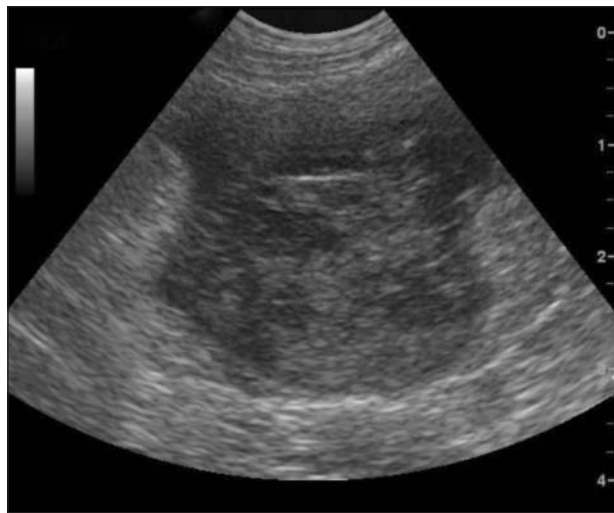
Transverse ultrasonographic image of the abdomen of a 3.7-year-old rabbit that was evaluated because of anorexia and lack of fecal production during the preceding day; on physical examination, palpation of the cranial portion of the abdomen elicited signs of pain and gas was palpable in the stomach. In this view, the caudate liver lobe is enlarged with rounded margins and marked heterogeneity of the parenchyma. Surrounding hyperechoic adipose tissue is also visible. On the basis of the abdominal ultrasonographic findings, a diagnosis of liver lobe torsion was made. Numbers at the right side of the image represent depth in centimeters.
